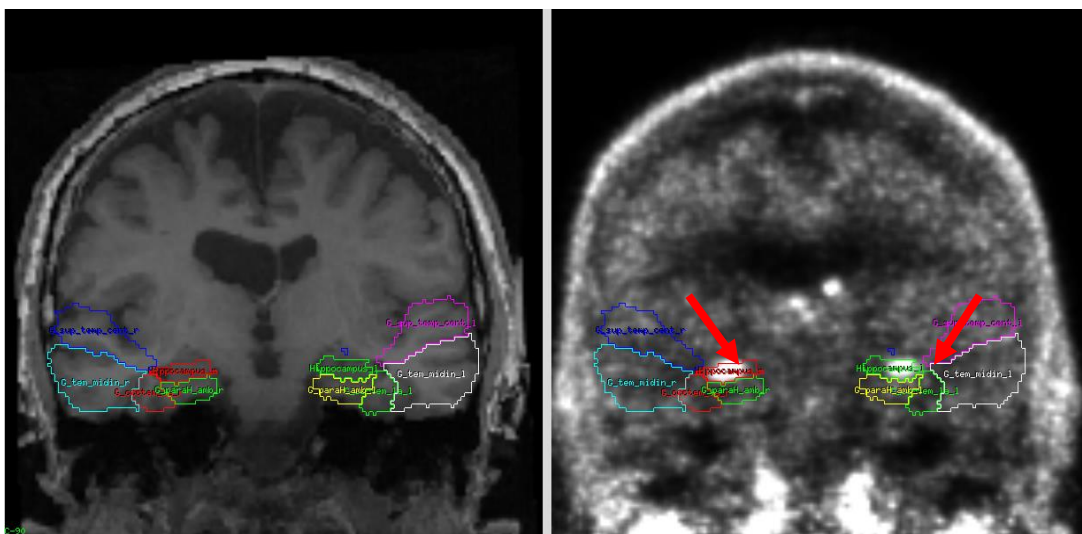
T1-weighted MR image and VPM-PET summation image
